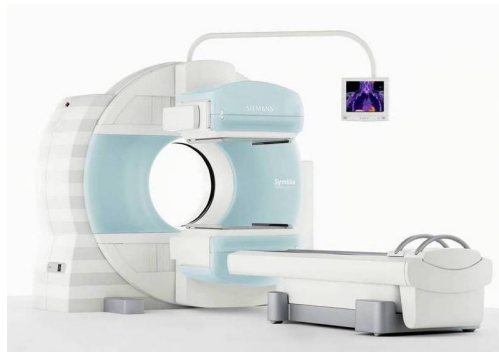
Siemens Symbia T6 SPECT/CT imaging system. Note: Image from *Siemens Healthineers*, 11-19-2020, <https://www.siemens-healthineers.com/en-us/molecular-imaging/spect-and-spect-ct/symbia-t>
